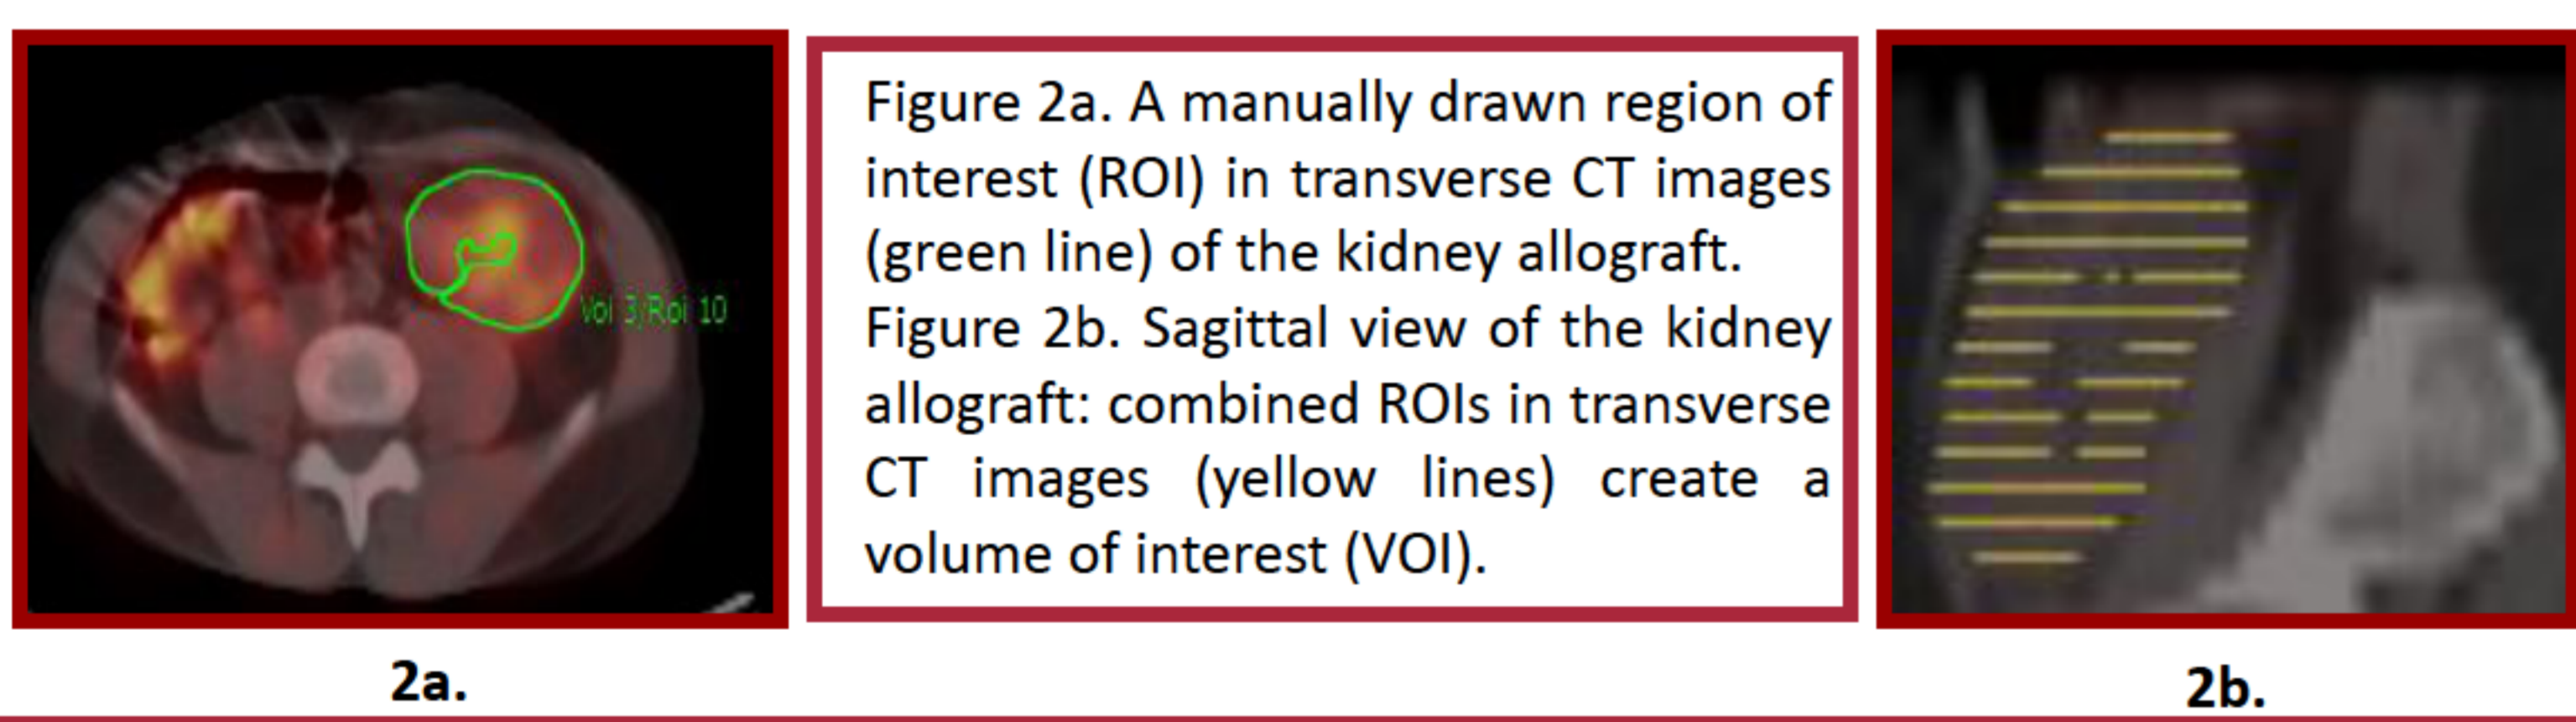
A manually drawn region of interest (ROI) in transverse CT images (green line) of the kidney allograft. Figure 2b. Sagittal view of the kidney allograft: combined ROIs in transverse CT images (yellow lines) create a volume of interest (VOI).
